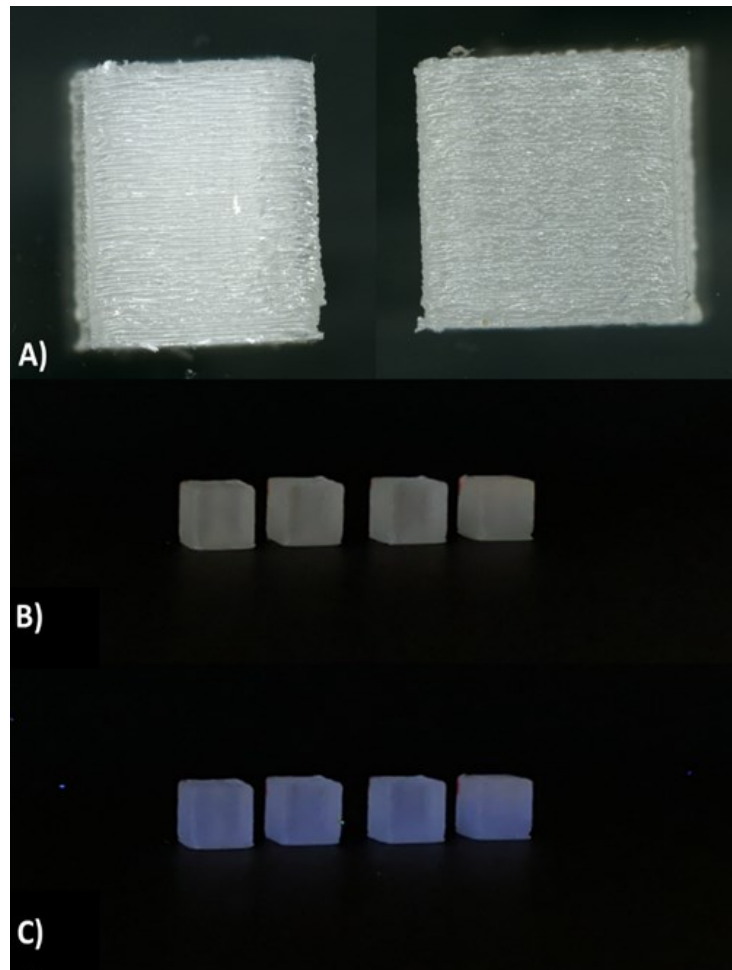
Images of novel 3D printed plastic scintillators, A) high-resolution optical scan taken with an Epson 10000 flatbed scanner, B) ordinary state and C) irradiated state, irradiated by 6 MV X-rays.
